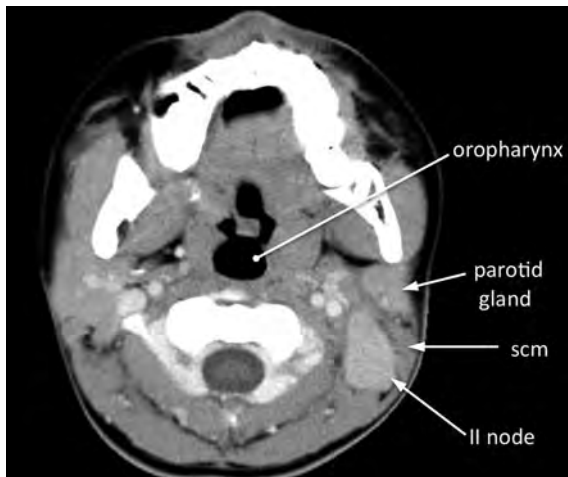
Axial CT post contrast showing an enlarged homogeneous left level II lymph node. This was diagnosed as Castleman's disease
